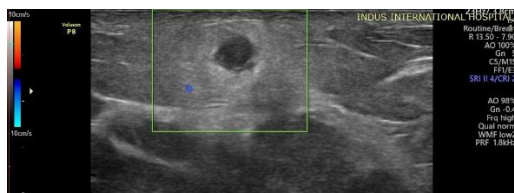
Colour Doppler shows no obvious internal vascularity
